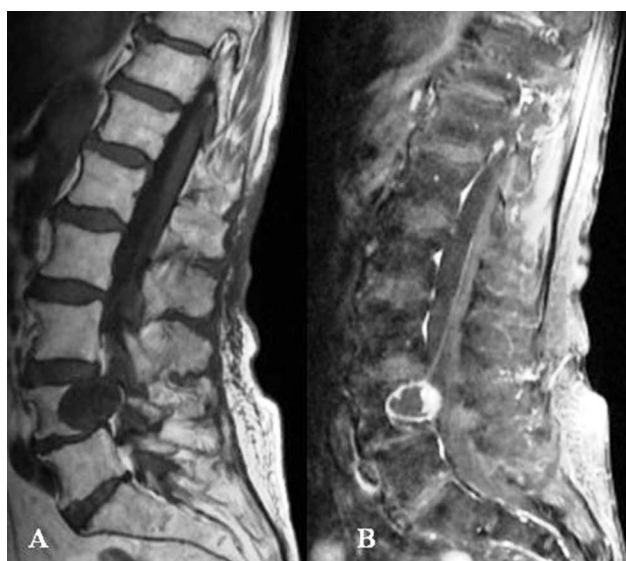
Sagittal MRI views of a neurofibroma at the level of L4: A) T1 without enhancement – hypointense signal; B) T1 with contrast – peripheral accumulation of contrast material.
